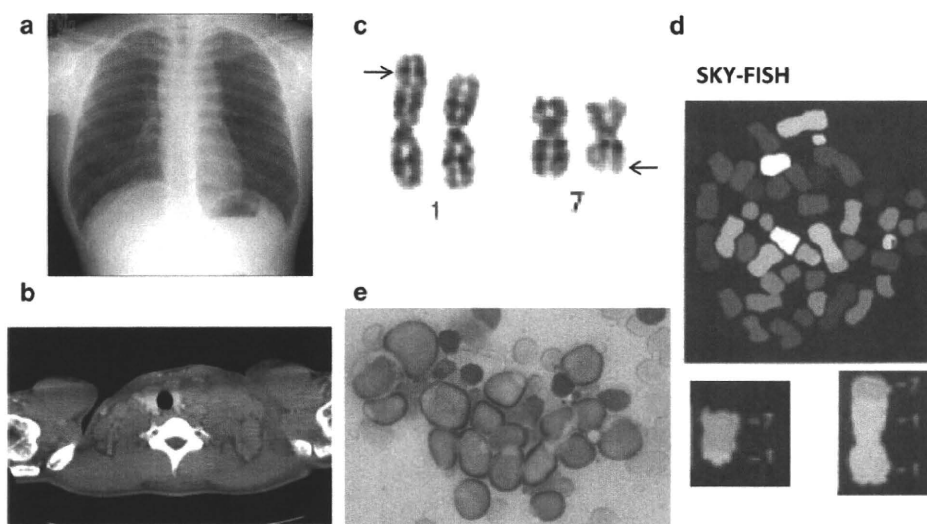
a Plain chest X-ray of the case at presentation. Upper mediastinum is enlarged. b CT scan also revealed segmented multiple nodules that fill upper mediastinum. c G-banding karyogram of the biopsied lymph node tissue. The balanced translocation, $t(1;7)(p34.1;q22)$, is shown. *Arrows* indicate the breakpoints of both
